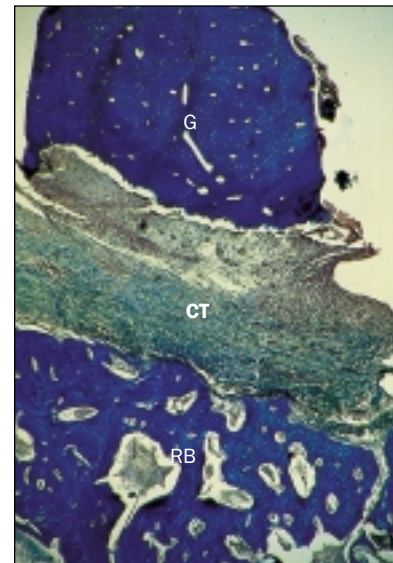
Decorticated bed at 45 days. The osseous graft (G) is not integrated, with connective tissue (CT) interposed between the graft and the receptor bed (RB) (Masson's trichomic; magnification $\times 25$).
